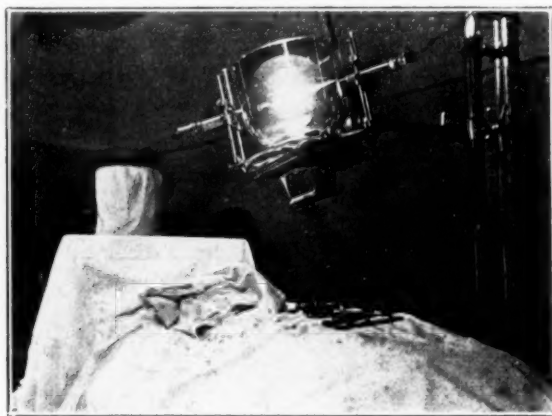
Application of the x-ray treatment. Patient in moderate Trendelenburg position under avertin anesthesia.
